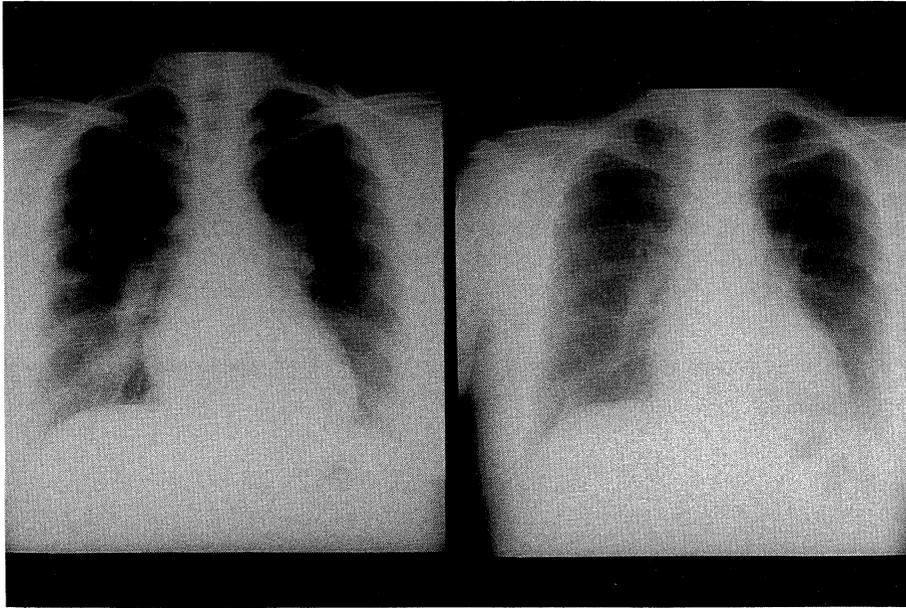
A preoperative chest X-ray film (left side) showed dilatation of a bilateral pulmonary arterial shadow and no vascular marking in the bilateral lung fields. A postoperative chest X-ray film (right side) showed more increment of bilateral vascular marking than preoperatively.
